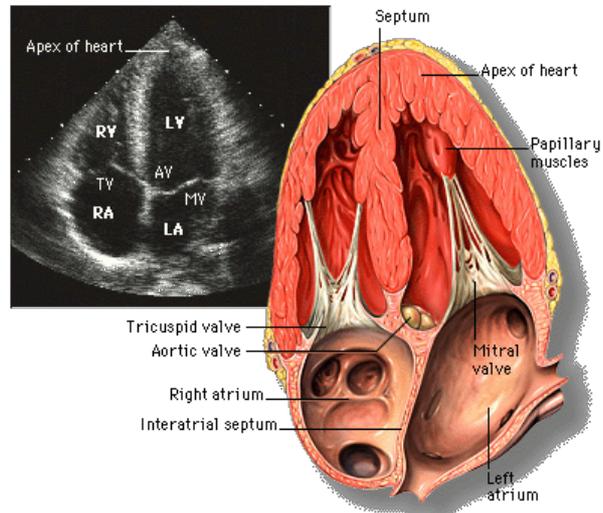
Apical 4 chamber view: http://www.med.yale.edu/intmed/cardio/echo_atlas/contents/index.html
